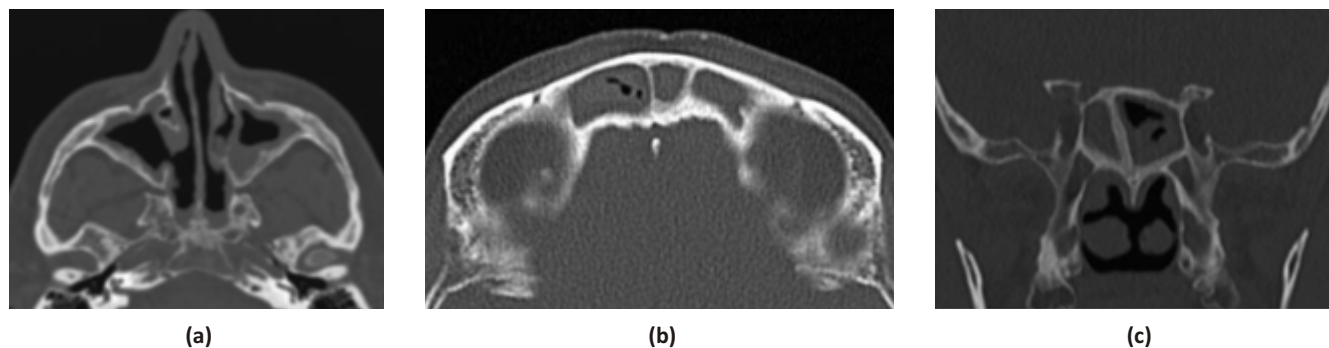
CT images of osteitis (a) maxillary, (b) sphenoid, and (c) frontal sinus.<sup>3</sup>
